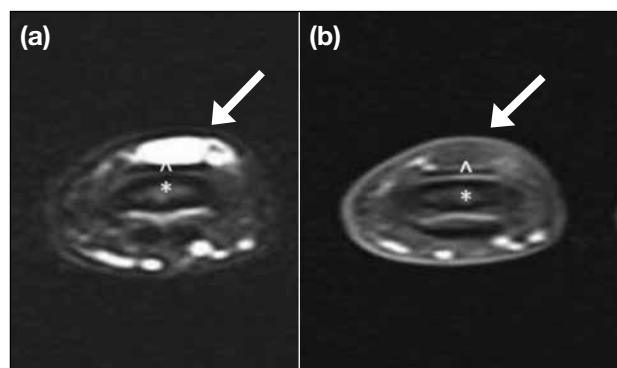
Ganglion cyst in a 40-year-old woman who presented with right middle finger mass: (a) T2-weighted axial magnetic resonance image showing marked hyperintense well-circumscribed lobulated lesion (arrow) over the dorsal aspect of the middle finger, at the distal phalanx (asterisk) level. The lesion is seen abutting and dorsal to the extensor tendon (arrowhead). (b) Post-contrast T1-weighted axial fat-saturated magnetic resonance image showing no contrast enhancement.
